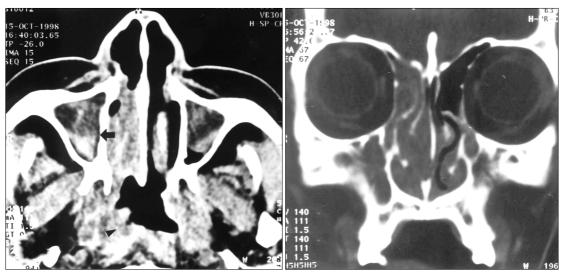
PNS computerized tomography (CT). A: Axial view through the RosenmEller fossa showed soft tissue densities in both maxillary sinuses and heterogeneity especially in right maxillary sinus (arrow). Right nasal cavity was filled with soft tissue density which was extending into the nasopharynx and obliterating RosenmEller fossa (arrowhead). B: In coronal view, whole nasal cavity and sinuses of right side were filled with soft tissue density.
